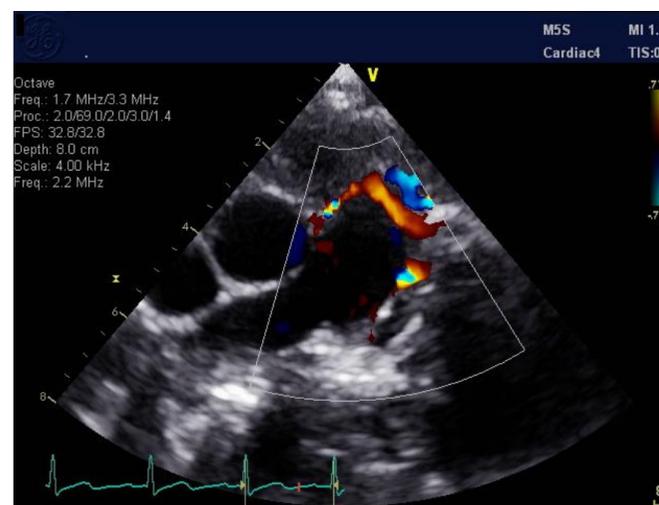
collateral flow entering the pulmonary artery was observed by Transthoracic echo.
